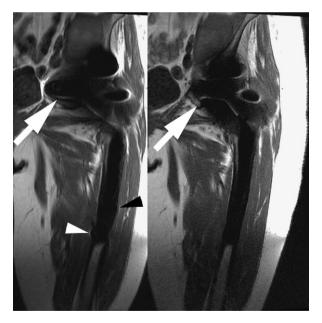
Coronal T1-weighted MRI of a left metalon-metal total hip arthroplasty. Part (a) was acquired using conventional fast spin-echo parameters and (b) was acquired using metal artefact reduction parameters described in the text. Mismapping of the signal from the femoral cortex (arrowheads) is nearly completely resolved by the MARS where the stem of the prosthesis lies parallel to B_0 . The mismapping of the signal from the neck and acetabulum of the prosthesis is reduced so that the superior pubic ramus (arrow) is discernible.
